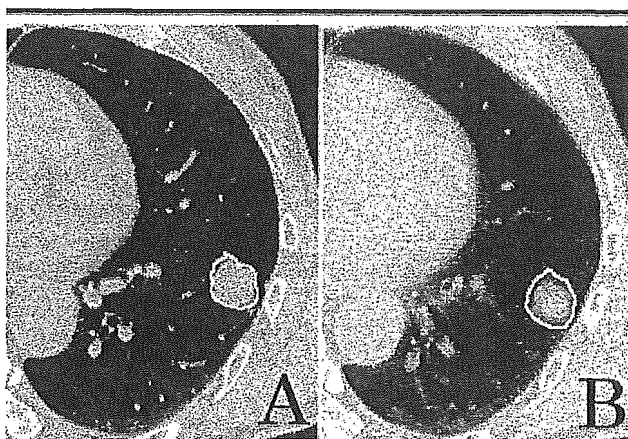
A, Transverse breath-hold thin-section CT image shows tumor contour (outline), tumor margin, and bronchovascular bundle. B, Transverse long-scan-time CT image shows delineation of tumor movement trajectory (outline) that includes ill-defined tumor margin.
